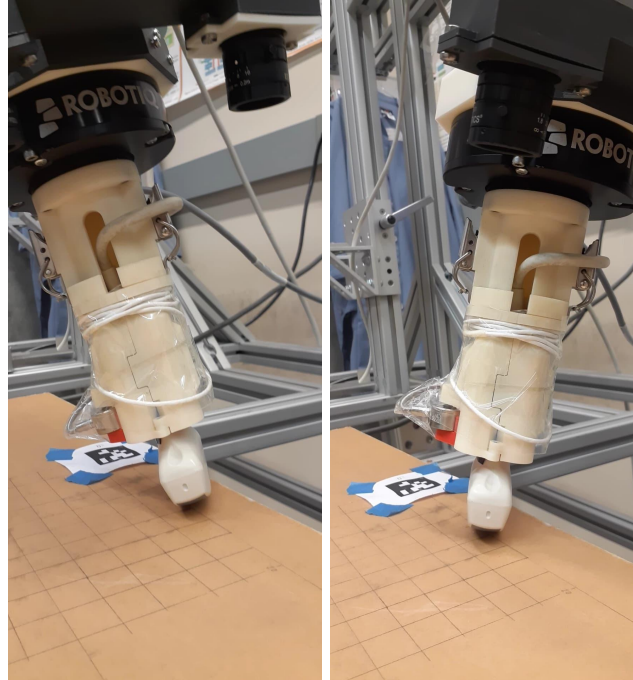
The ultrasound probe at each end of its 30 degree wobble motion.
